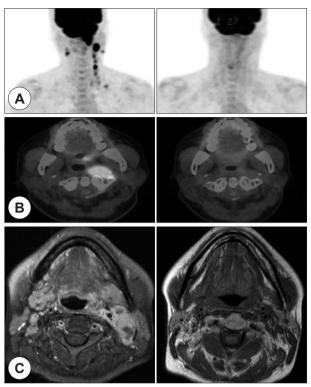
Evaluation of 18-FDG-PET scan(A and B), MRI(C) according to 3 cycle of chemoradiation treatment : completely disappeared mass and enlarged malignant lymph nodes.
